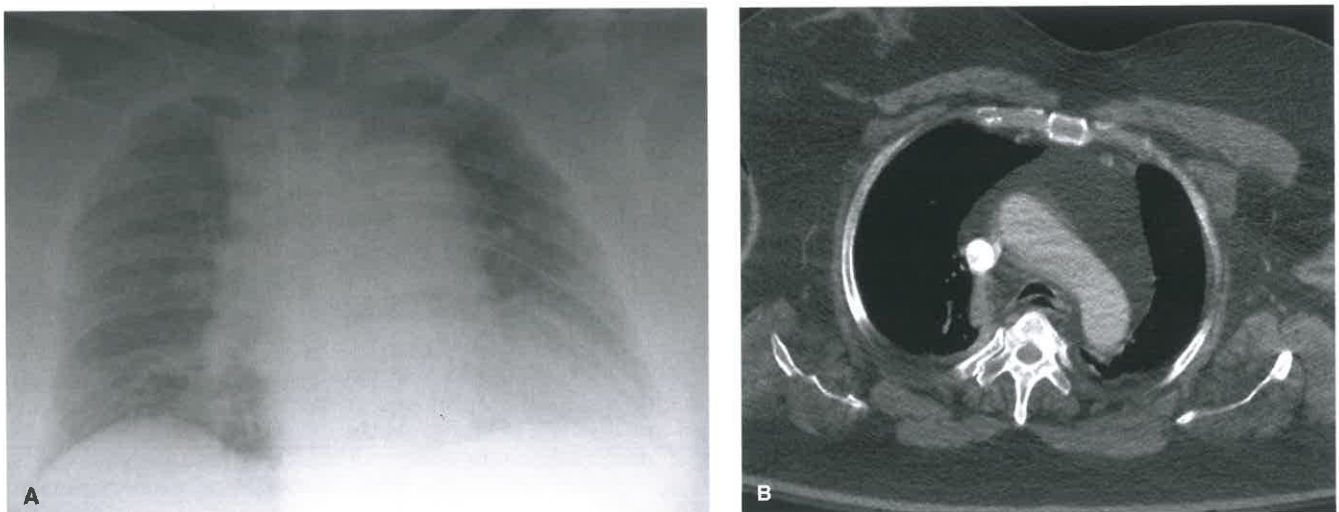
Mediastinal Lipomatosis. A: Frontal chest radiograph in a 54-year-old man shows a widened mediastinum. B: Axial contrast-enhanced CT at the level of the aortic arch shows abundant mediastinal fat accounting for the mediastinal widening on radiography.
